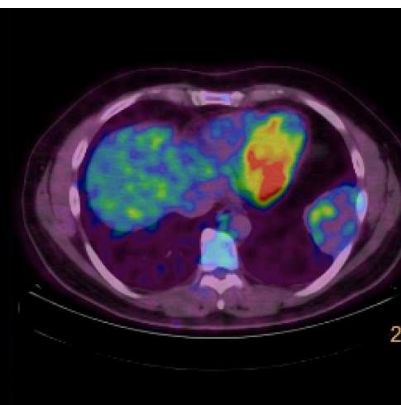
PET-CT showing a very heterogeneous pulmonary mass in the left lower lobe with moderate FDG uptake, invading the intercostal space.
